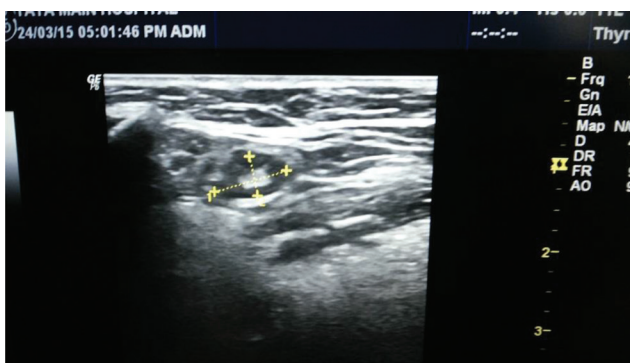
High-resolution ultrasound of neck of the first patient showing enlarged right cervical lymph node.
